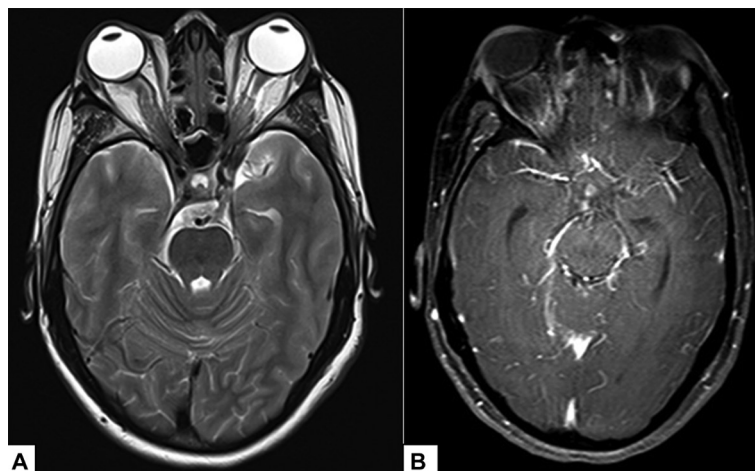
(A) MRI image. T2 sequence showing thickened cranial nerves—bilateral optic nerve, left trigeminal nerve in Meckel's cave. (B) Postgadolinium-enhanced axial images of MRI brain showing leptomeningeal enhancement.
